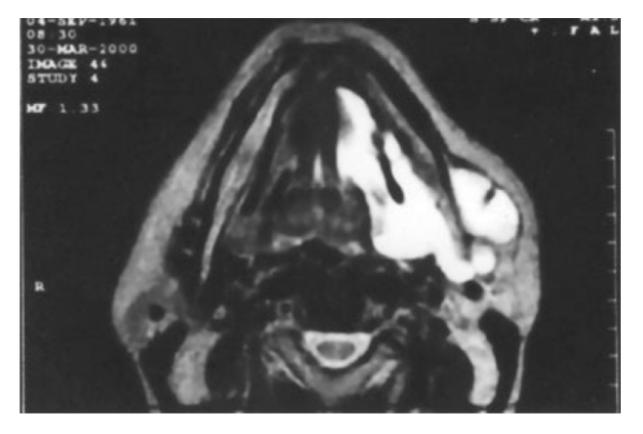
Axial T2-weighted magnetic resonance image (TR/TE 5000/96) showing a high–signal intensity collection of fluid in the floor of the mouth and extending behind the mandibular ramus and lateral to the mandibular angle.
